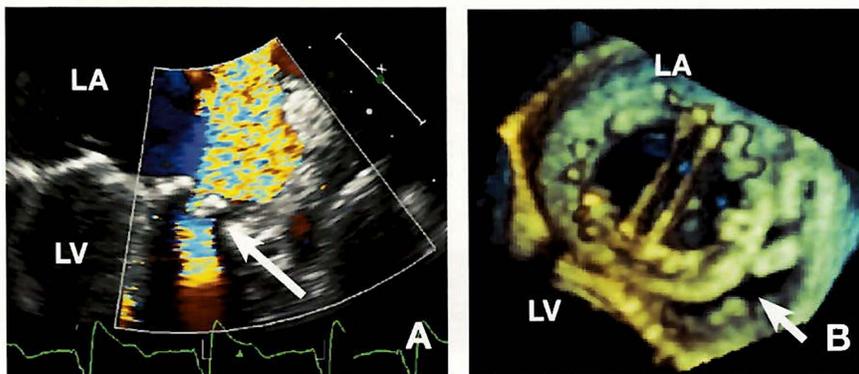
Anatomic insight into the 3D geometry of paravalvular defects. A bi-leaflet (St. Jude) mechanical mitral valve with 2D and color Doppler TEE assessment of a large paravalvular defect along the antero-lateral portion of the annulus (panel A, shown in systole). Live 3D TEE cropped to create a lateral view of the defect (arrow) at the origin of the LA appendage (Panel B, shown in diastole). Left atrium (LA); left ventricle (LV). Precise localization of the paravalvular defect as well as live 3D catheter guidance is now making percutaneous paravalvular repair an alternative to reoperation for some patients with significant paravalvular regurgitation.
